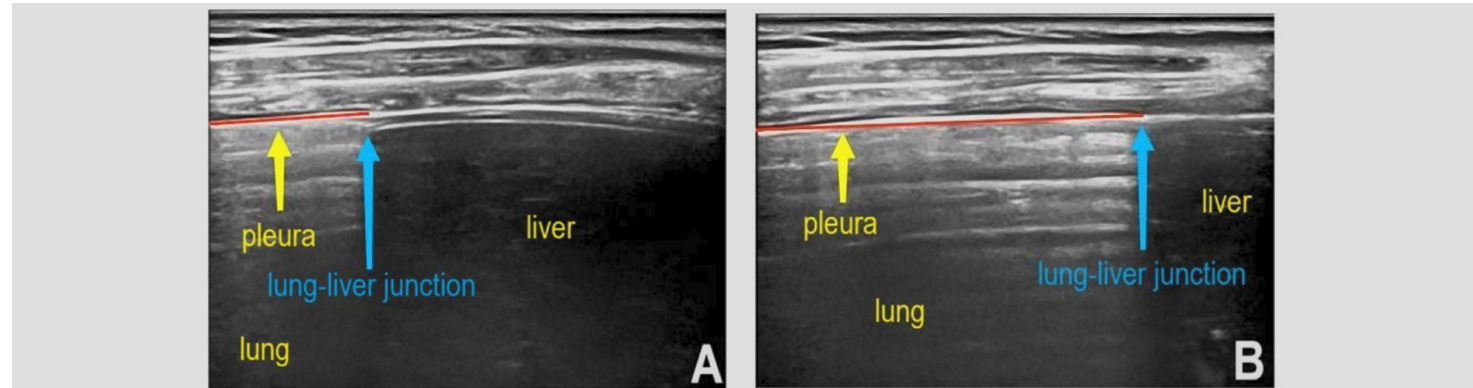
Pleural sliding displacement (PSD) measurement method. (A) The distance between the lung–liver junction and the left edge of the acoustic window of the ultrasound instrument was measured along the pleural line at the end of expiration. (B) The distance between the lung–liver junction and the left edge of the acoustic window of the ultrasound instrument was measured along the pleural line at the end of inspiration. The difference between the two values is the PSD.
